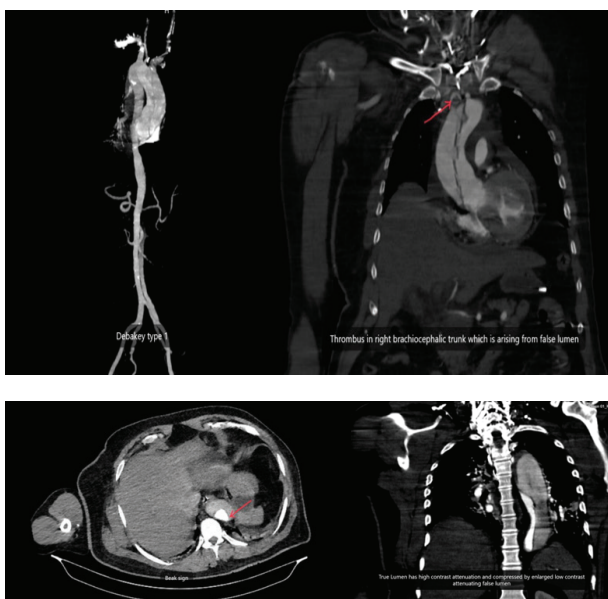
Computed tomography angiography (CTA) of the chest.
